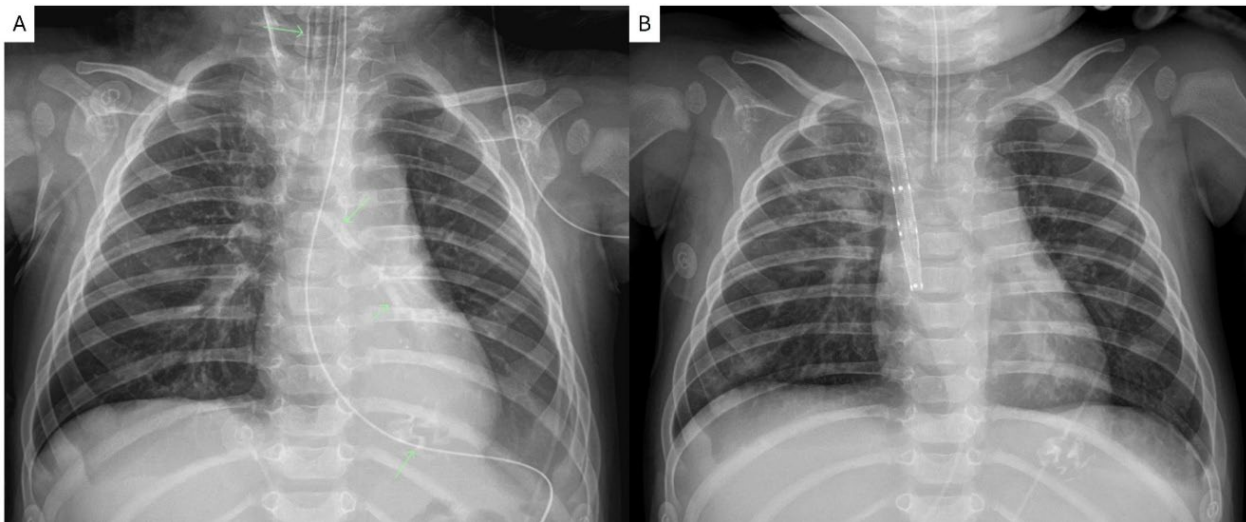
X-ray Before and After Bronchoscopy
